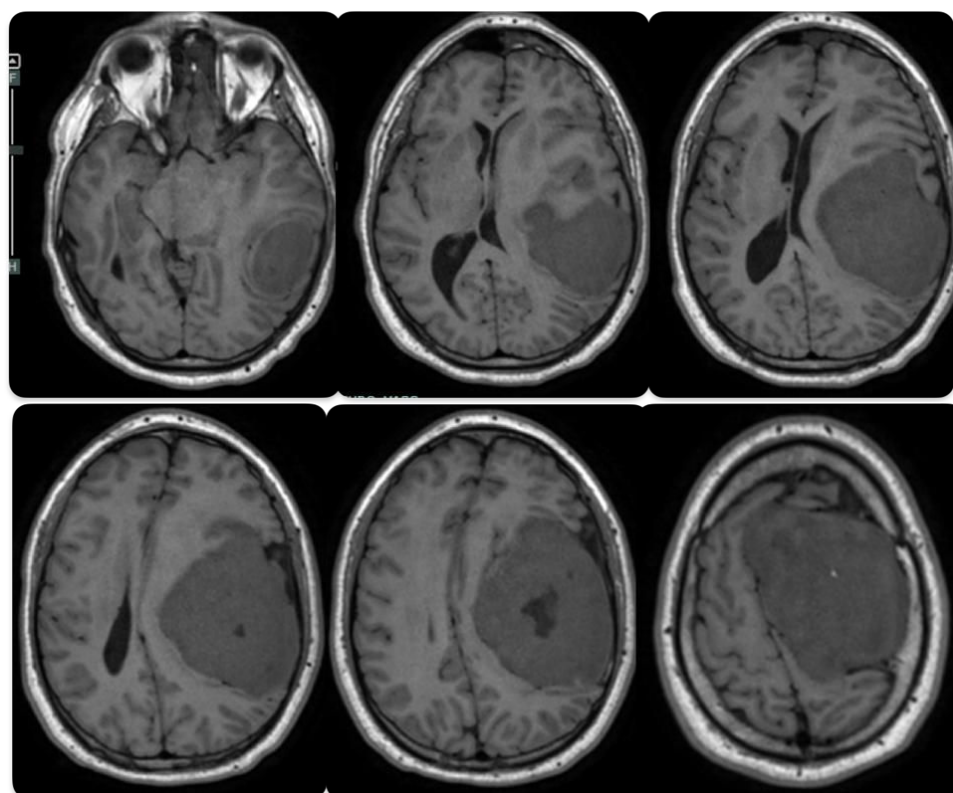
Preoperative MRI. MRI brain axial T1 shows Large left frontal extra-axial mass: Iso- to hypointense on T1 with a dural-based broad attachment, the lesion causes marked compression of the adjacent brain parenchyma, including rightward midline shift and effacement of the left lateral ventricle.
